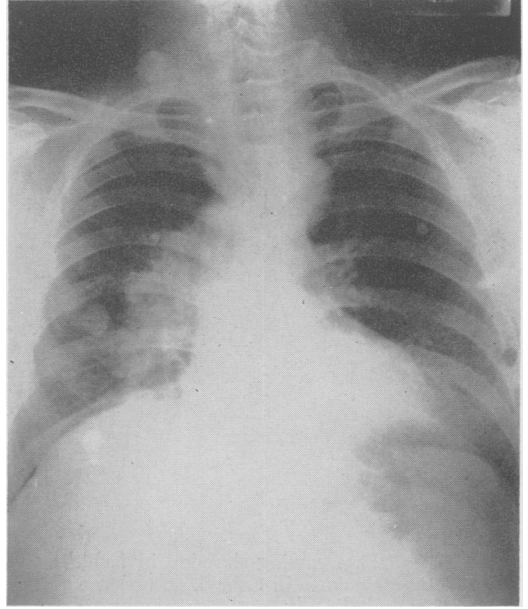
Roentgenogram of chest in Case 6, made one year previously, showing moderate prominence of the aortic shadow but no evidence of aneurysm formation. A broncho-pneumonic process is demonstrated on the right.
